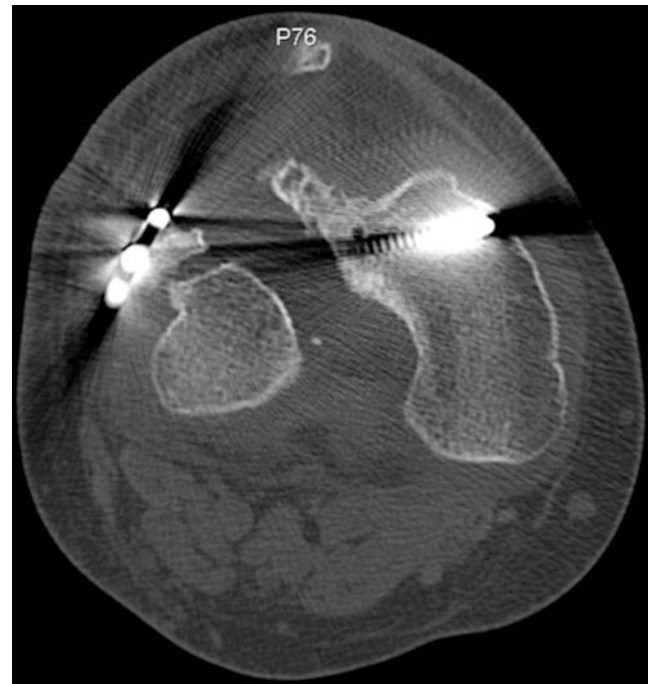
CT scan obtained to better define the size and margins of the lateral femoral condyle articular cartilage defect
